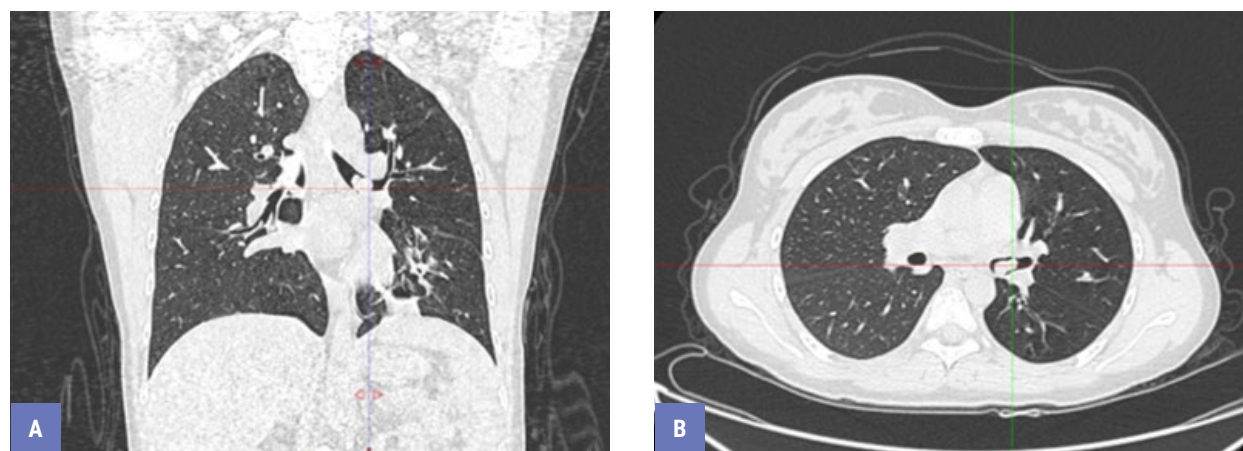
Chest CT scan of the patient G.: A – frontal section; B – sagittal section
